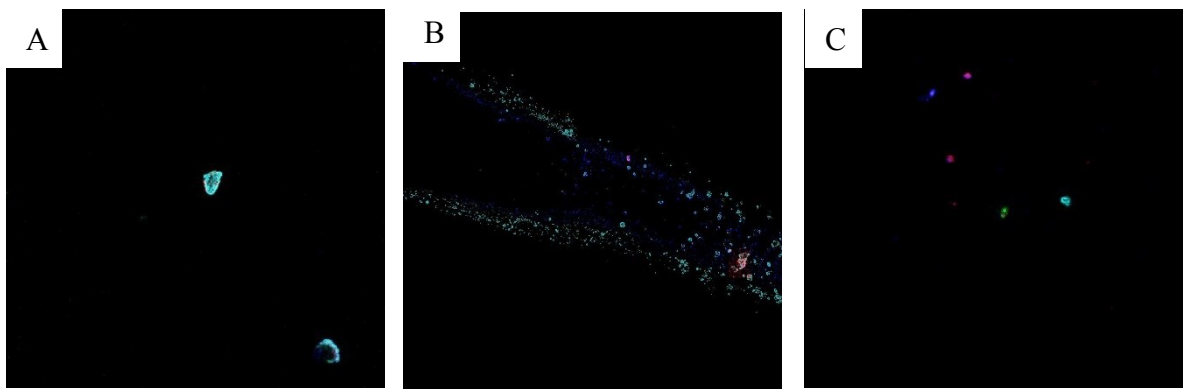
Confocal images of biofilm following the Passive Ultrasonic irrigation. There are no noticeable amount of bacteria detectable in coronal third (A), middle third (B), and apical third (C).
